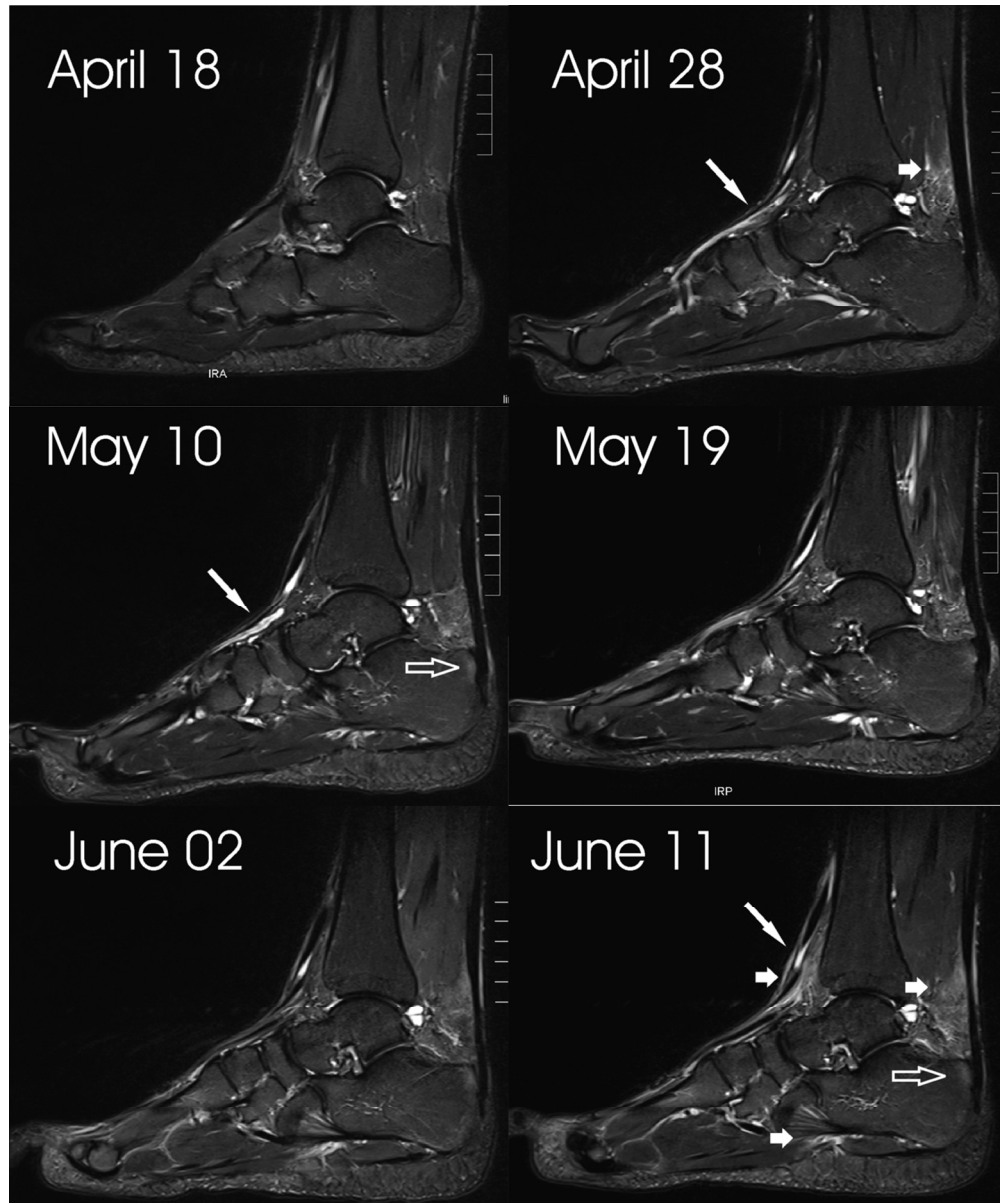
Subcutaneous edema on a sagittal STIR weighted MRI scan.
